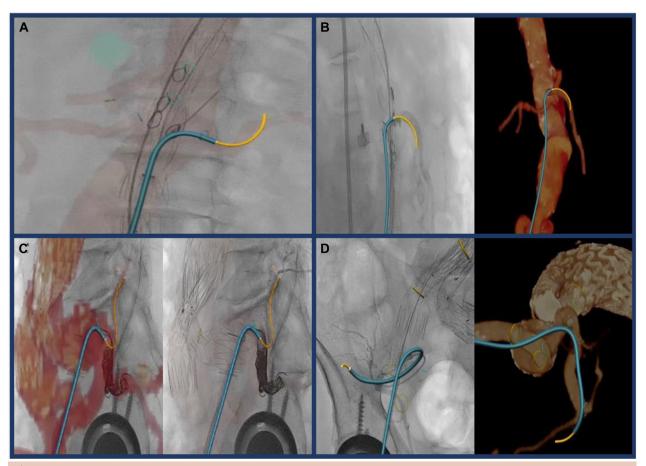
Representative images of fiber optic RealShape (FORS) use. (A) Navigation through left renal fenestration of physician-modified endograft (PMEG) into distal portion of artery using FORS wire and catheter in conjunction with live fluoroscopy and image overlay. (B) Navigation through superior mesenteric artery fenestration of PMEG with FORS wire and catheter in conjunction with live fluoroscopy with hand injection of contrast and three-dimensional computed tomography (CT) reconstruction. (C) Navigation into hypogastric branch for embolization using fluoroscopy with image fusion and hand injection of contrast. (D) Navigation into distal hypogastric using FORS wire and catheter with live fluoroscopy with hand injection of contrast and three-dimensional CT reconstruction.
